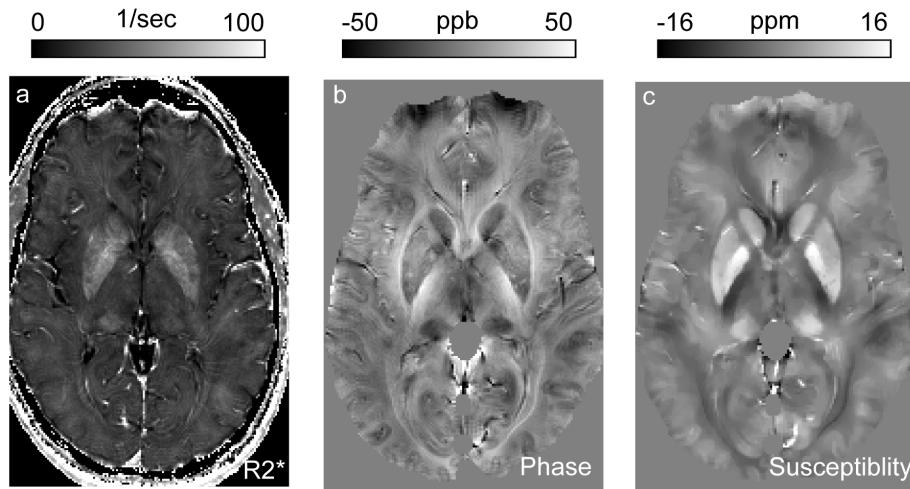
MRI images from a 45 year old healthy male of deep grey matter including the head of the caudate nucleus, globus pallidus, and putamen. a)  $R2^*$  map b) phase image processed with SHARP and c) susceptibility map using L2 regularization. Hyperintense phase surrounds the putamen, globus pallidus and head of the caudate in the phase image due to external field effects from these structures. The outer surface of the brain is removed using the SHARP method. Tissue is smooth in the susceptibility map due to regularization parameters while the same regions are heterogeneous in the  $R2^*$  map. Images obtained from a multi-echo gradient echo sequence using a 4.7T system [11].
